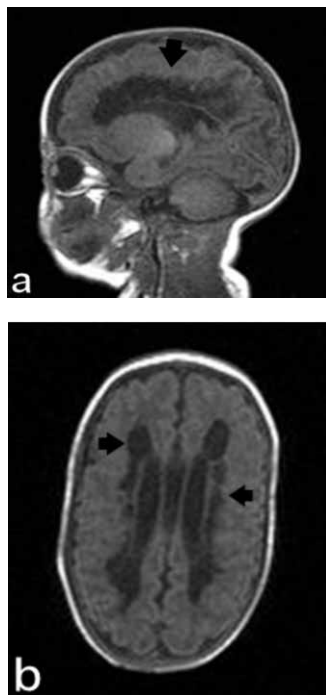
a) Magnetic resonance imaging scan of preterm infant at 4 months of age with cystic PVL and subsequent evolution of epileptic encephalopathy. Note the appearance of cystic formations (black arrow). b) Magnetic resonance imaging scan of the same preterm infant showing cystic formations and ventriculomegaly (black arrows).
